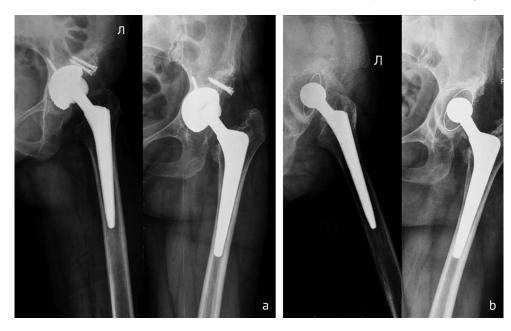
Radiographs of the left hip joint in lateral and frontal views: *a* 6 months after primary arthroplasty (signs of instability of the cementless pelvic component); *b* 6 months after revision arthroplasty with replacement of the cup with a cemented system (instability of the cemented pelvic component)
